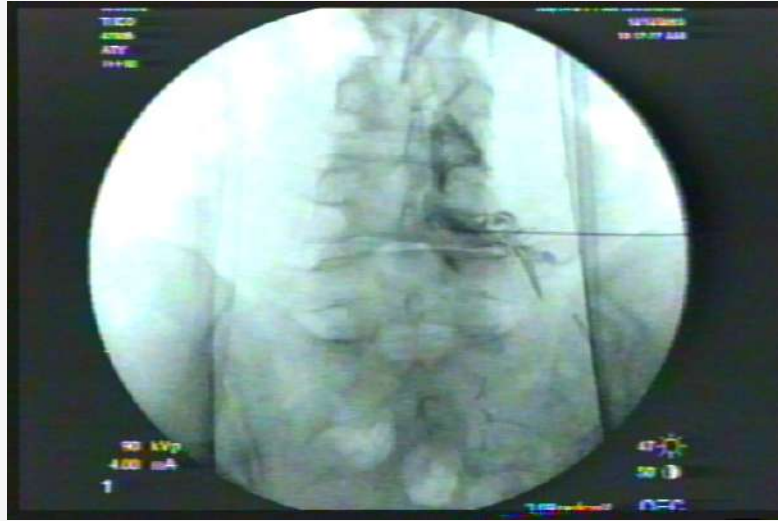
A diagnostic and therapeutic epidural gram may help identify unrecognized lateral recess stenosis underestimated by MRI. An excellent result from a therapeutic block lends excellent prognosis for a more lasting and “permanent” result from transforaminal endoscopic lateral recess decompression.
